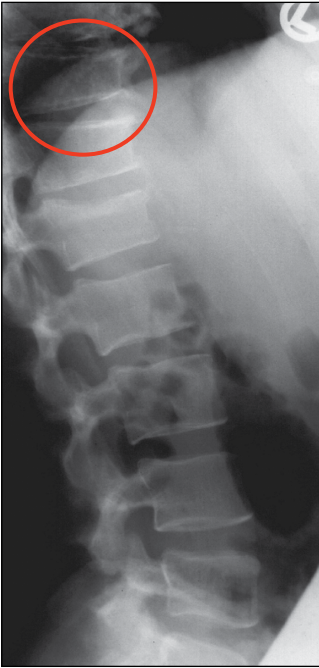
Fractures of the thoracic and lumbar vertebrae as a direct consequence of muscle contractions occurring during generalized tonic-clonic convulsions are the most common nontraumatic type of fracture complicating epileptic seizures. The majority of these fractures are vertebral compression fractures that occur with minimal symptoms and virtually no permanent neurological sequelae. Any patient who is reporting lower back pain following a tonic-clonic seizure needs to have an x-ray for diagnosis of a vertebral fracture of the thoracic-lumbar region. In rare cases, however, muscle contractions generated during generalized motor seizures can result in severe axial skeletal trauma and grave neurological complications (with permission from Elger and Schmidt, 2008).
